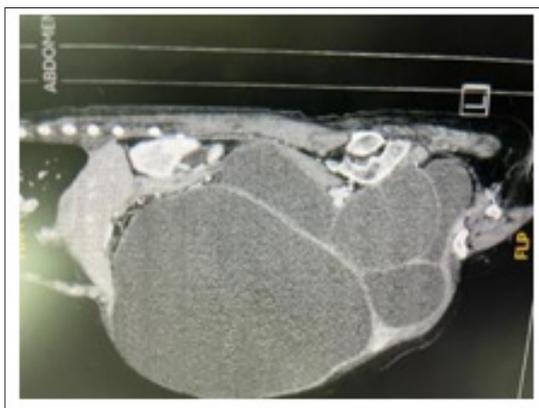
CT Finding of Huge Conglomerated Cyst
